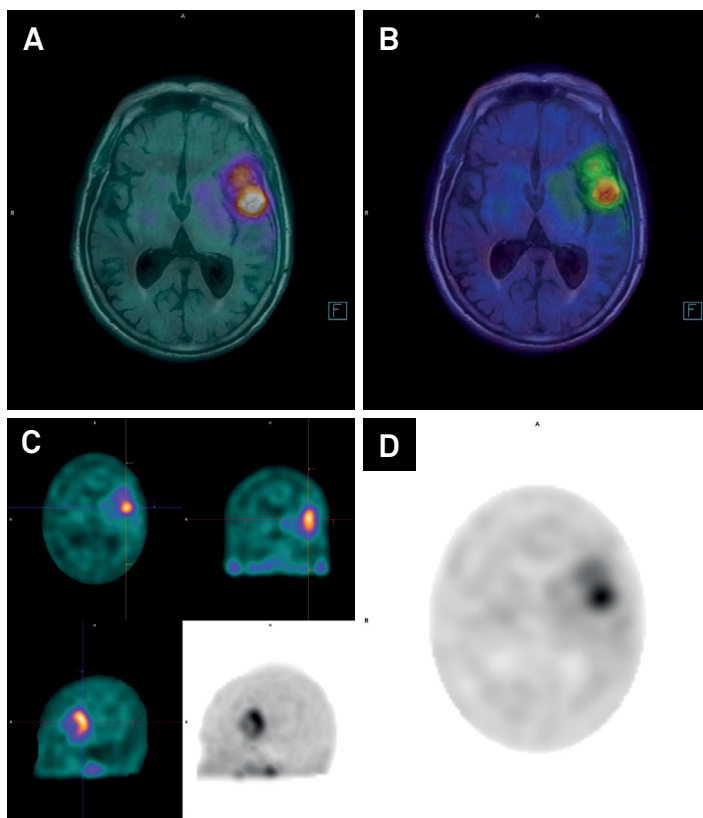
Dopamine transporter (DAT) imaging with SPECT/CT was performed four hours after IV injection of 1110 MBq (30 mCi) of ^{99m}Tc -TRODAT-1. Fused SPECT/MRI axial slices (A and B) and SPECT (C and D). The study revealed significant reduction of radiotracer uptake in the striatum bilaterally. As well, a remarkable uptake of the radiopharmaceutical can be seen in the tumoral left frontal extra-axial mass. SPECT: single-photon emission computed tomography; MRI: magnetic resonance imaging; CT: computed tomography.
